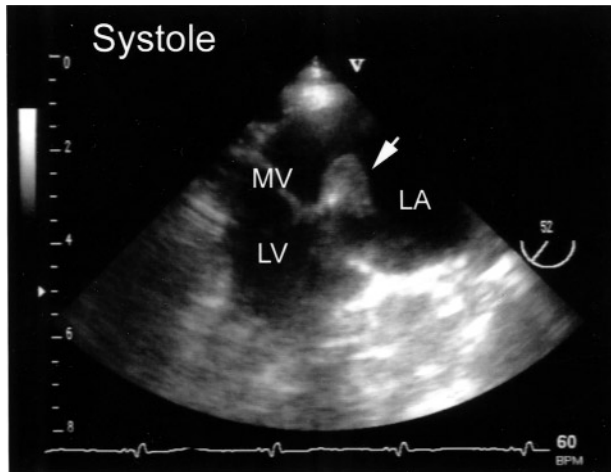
Transesophageal echocardiogram. A large 12 × 15 mm mobile lesion (arrowhead) is attached to the posterior leaflet of the mitral valve. In diastole it is prolapsing into the left ventricle. LA: left atrium, LV: left ventricle, MV: mitral valve, arrowhead: rheumatoid nodule.
